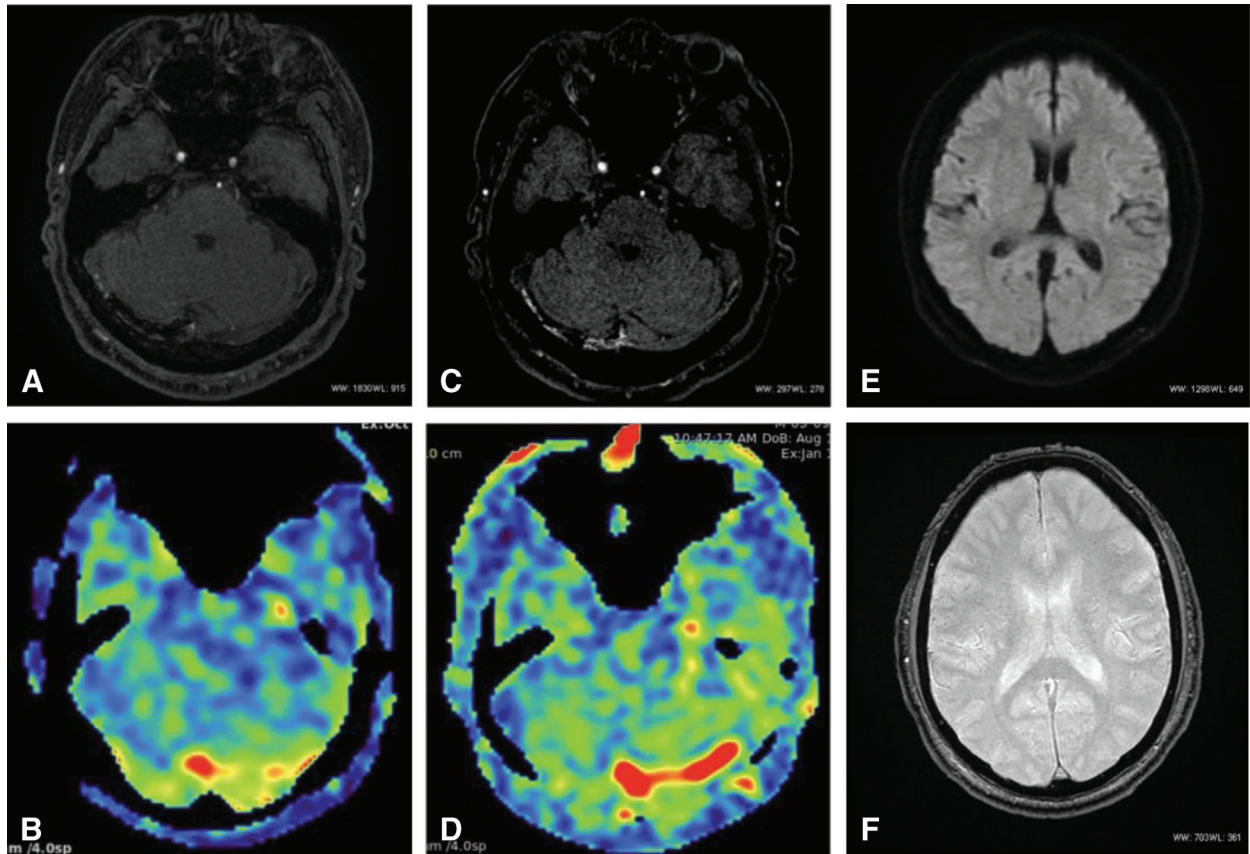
MRI imaging after embolization: 5 days after embolization and 3 months after embolization. (A) TOF-MRA source imaging 5 days after embolization shows the slight hyperintensities in the sinus confluence. (B) ASL imaging 5 days after embolization shows a high signal intensity in the sinus confluence. (C) TOF-MRA source imaging 3 months after embolization shows the increased hyperintensities in the sinus confluence. (D) ASL imaging 3 months after
